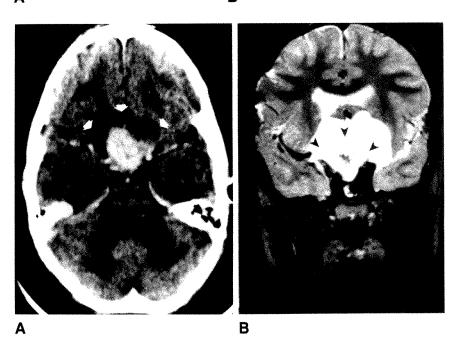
A, Contrast-enhanced axial CT scan shows strongly enhanced chiasmal pilocytic astrocytoma surrounded by multilobulated arachnoid cyst (arrows).
